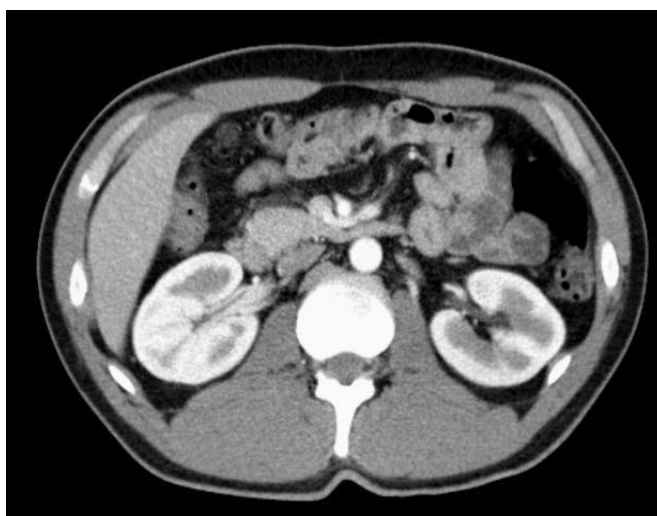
A cross sectional image of abdomen during abdominal CT imaging. Clear image of left and right kidney as well as aorta and intestine are helpful for clinical practice
